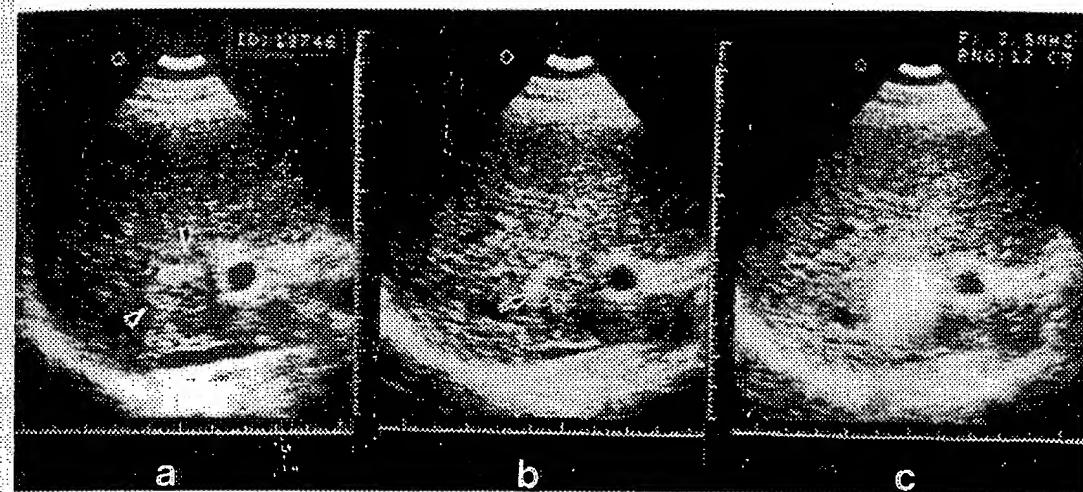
Percutaneous ethanol injection therapy (PEIT) under ultrasonographic guidance. a Small HCC (arrows); b The tip of a small needle is observed inserted into the small
